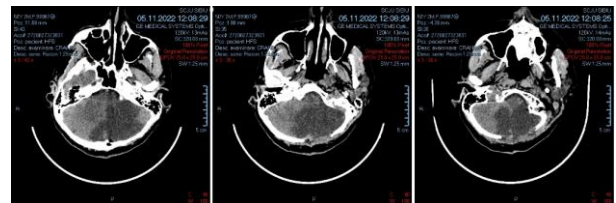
Native CT Head performed on 05.11.2022.
